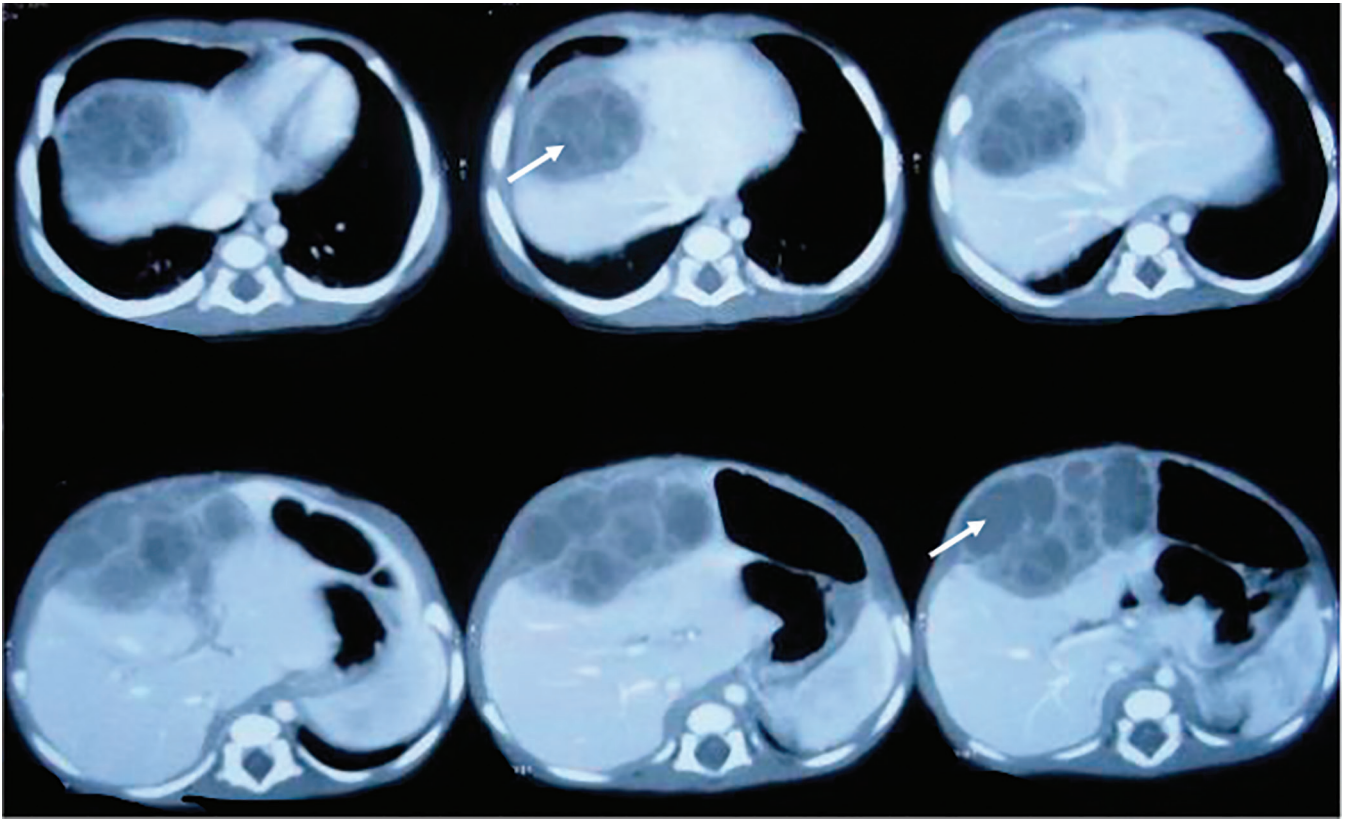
Abdominal CT scans of a patient showing liver abscesses (arrow)
